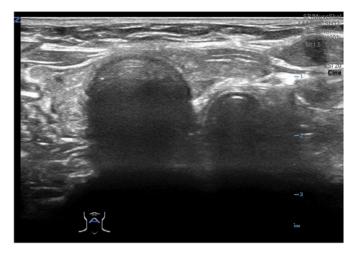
Esophageal intubation using grayscale ultrasound.
